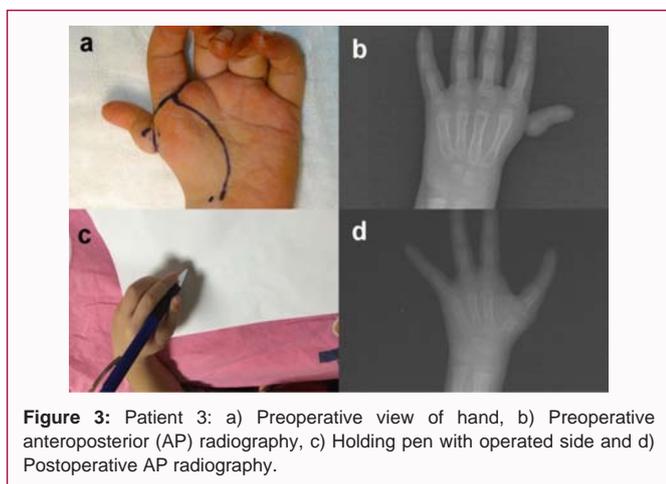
Patient 3: a) Preoperative view of hand, b) Preoperative anteroposterior (AP) radiography, c) Holding pen with operated side and d) Postoperative AP radiography.
